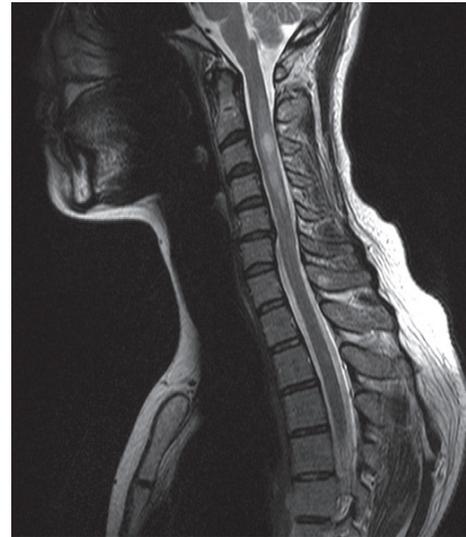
Sagittal T2-weighted image of the brain and cervical spine from a patient with multiple sclerosis. The image shows a high-signal plaque from C3-C5 in the spinal cord.
